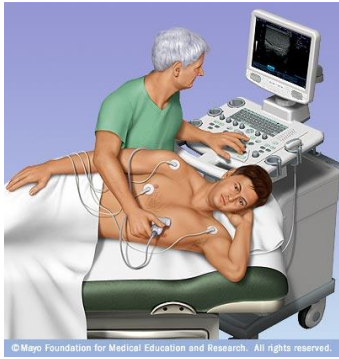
Echocardiogram procedure (Ref. Mayo Foundation for Medical Education and Research)
